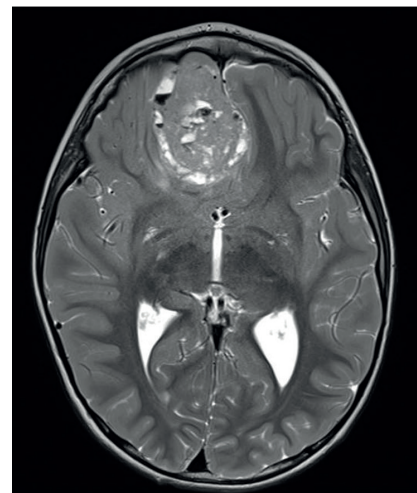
MRI showing large intracerebral mass.
